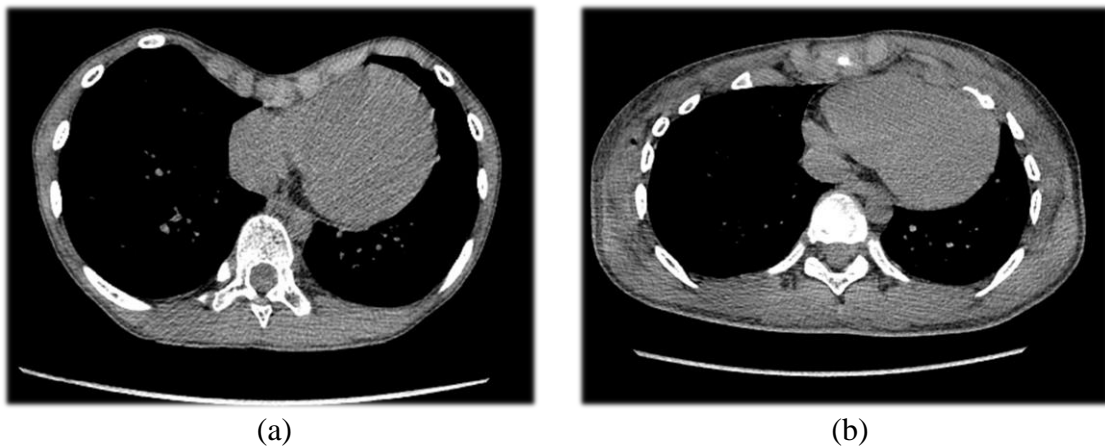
Computed tomography (CT) scan in axial plane for a patient with PE before (a) and after (b) the Nuss procedure surgery (courtesy of Beijing Children's Hospital).
